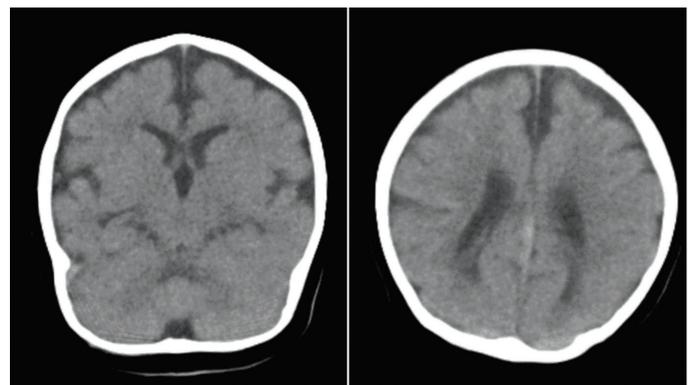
Brain computed tomography at the age of 9 months old
